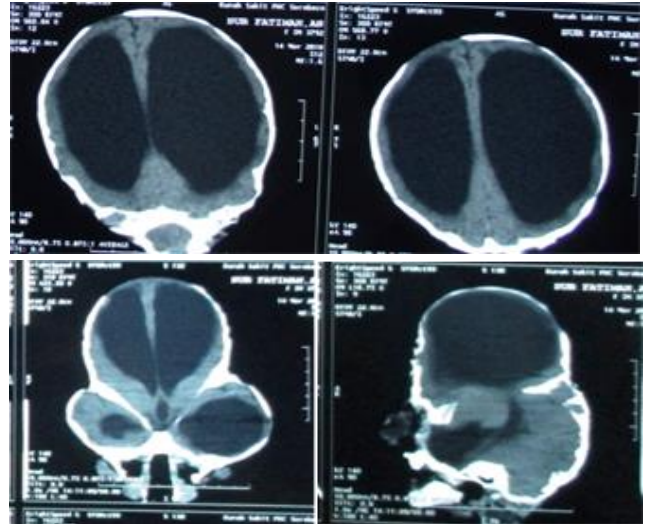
CT-Scan showed cloverleaf deformity and hydrocephalus
